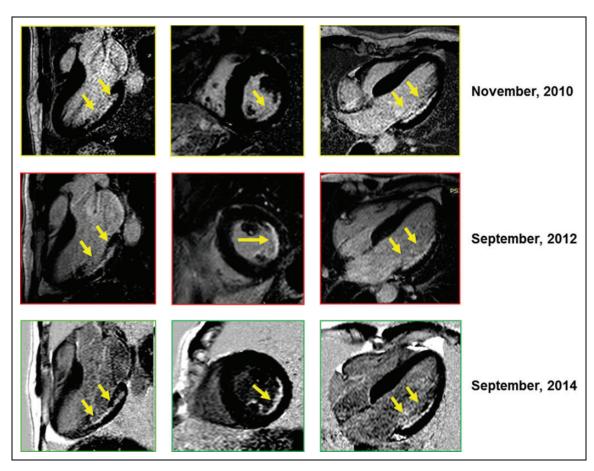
Cardiac magnetic resonance imaging (MRI) in patient with Fabry disease (FD) and history of inferolateral infarction—cardiac MRI is an excellent method to reveal the presence of fibrosis in FD, which is commonly located in the posterolateral basal and midlevel or subepicardial layers, but in this case, the late enhancement MRI shows subendocardial, anterolateral, and inferoposterior wall (basal and middle) enhancement in the area of circumflex coronary artery distribution (necrosis). Magnetic resonance imaging is an excellent method to guide the diagnosis, and on the other hand, it is one of the useful tools available to predict treatment response.
